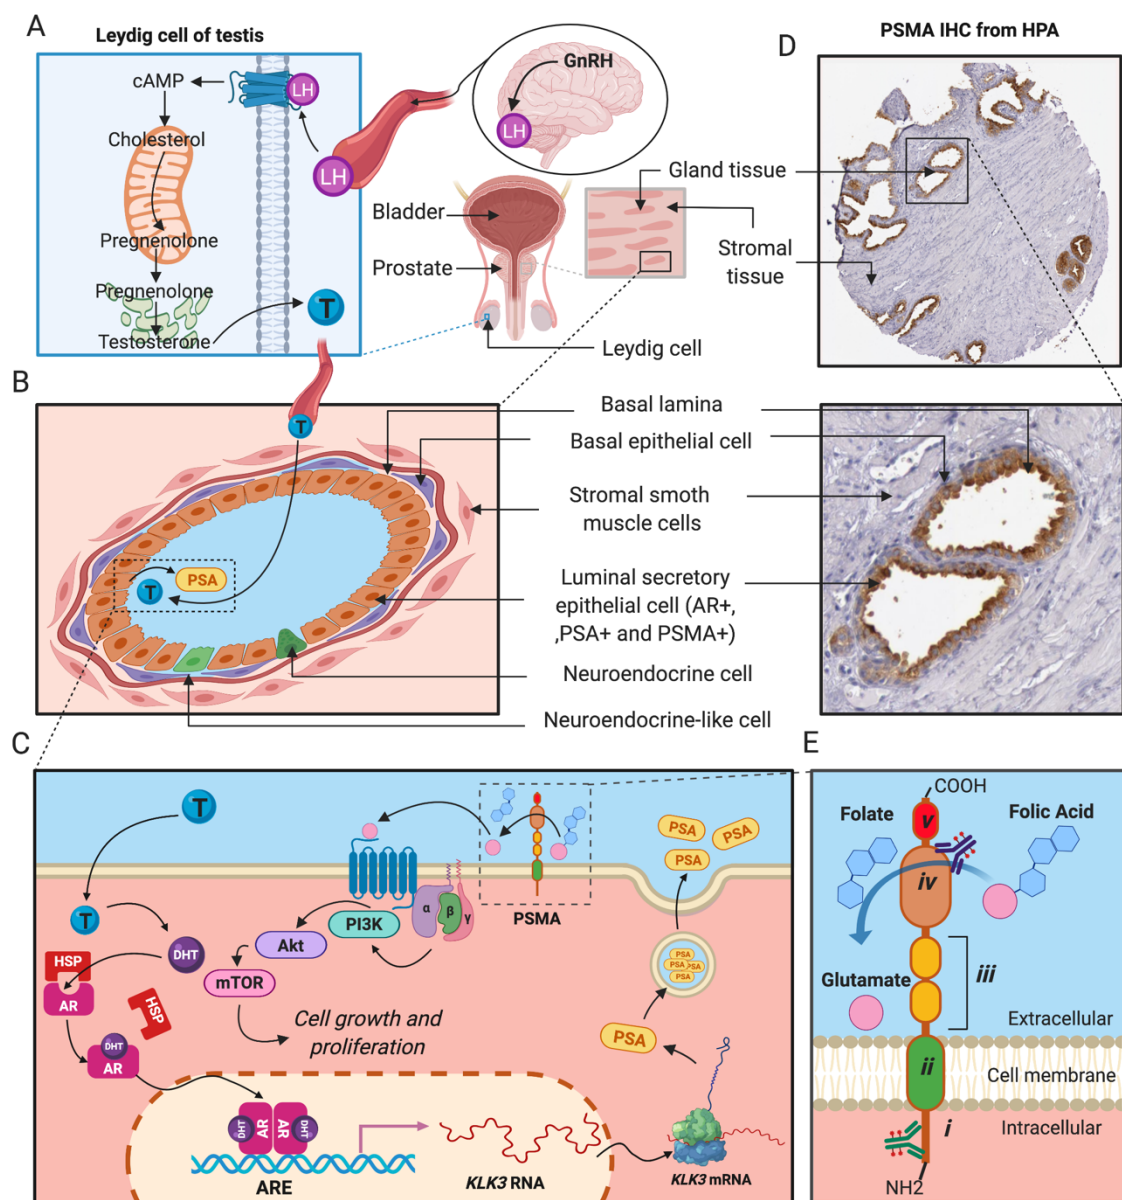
Leydig cell steroidogenesis and PSMA expression in prostate gland.
